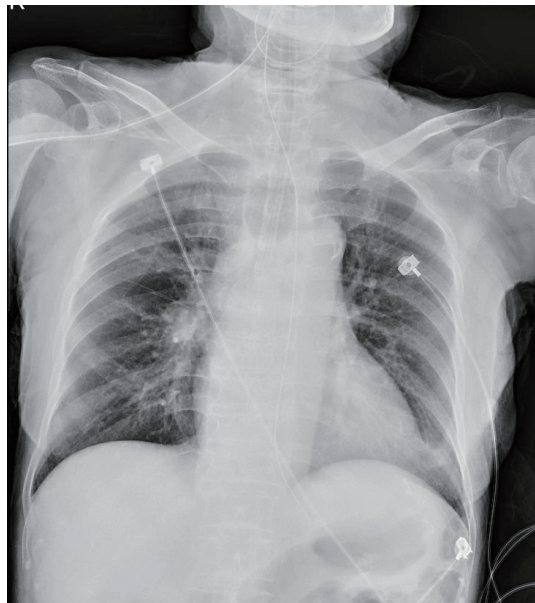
Chest plain film shows the tip of the endotracheal tube too close to the carina, with the cuff overinflated.
